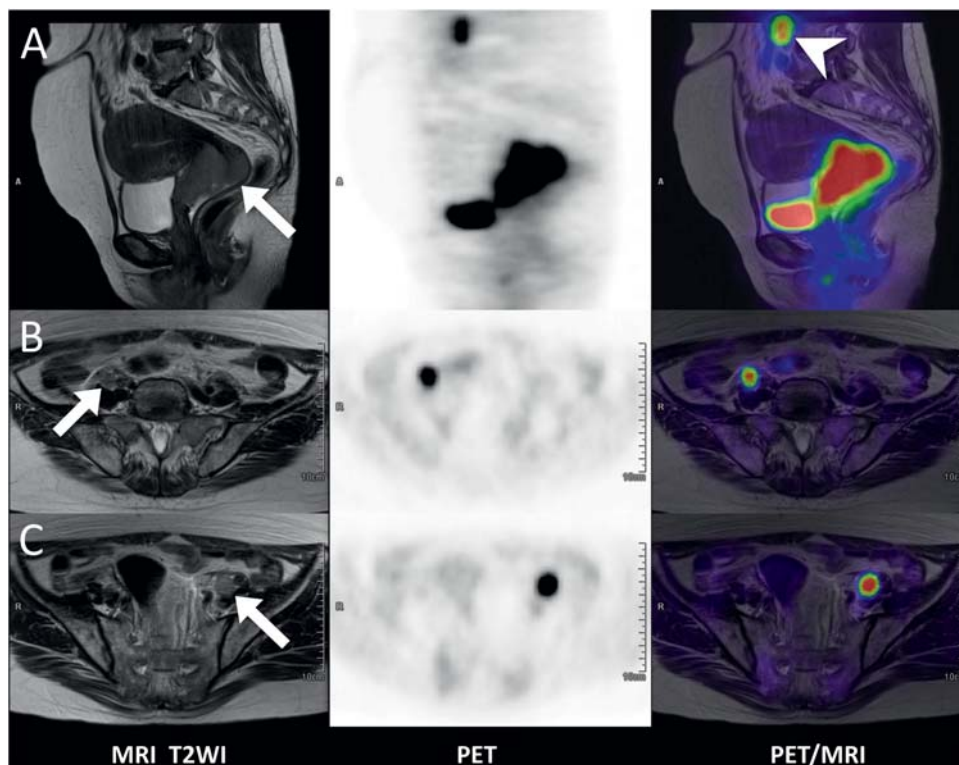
A 51-year-old woman with cervical cancer, squamous cell carcinoma, stage IIIB. (A) MRI, PET, and PET/MRI showing a large primary tumor at the uterine cervix (arrow), with high fluorodeoxyglucose (FDG) uptake ($SUV_{max} = 13.4$). Hypermetabolic iliac lymphadenopathy was also noted (arrowhead). (B) FDG-avid right iliac lymphadenopathy (arrow). (C) Left iliac lymphadenopathy (arrow). Bilateral iliac lymph nodes were precisely coregistered.
